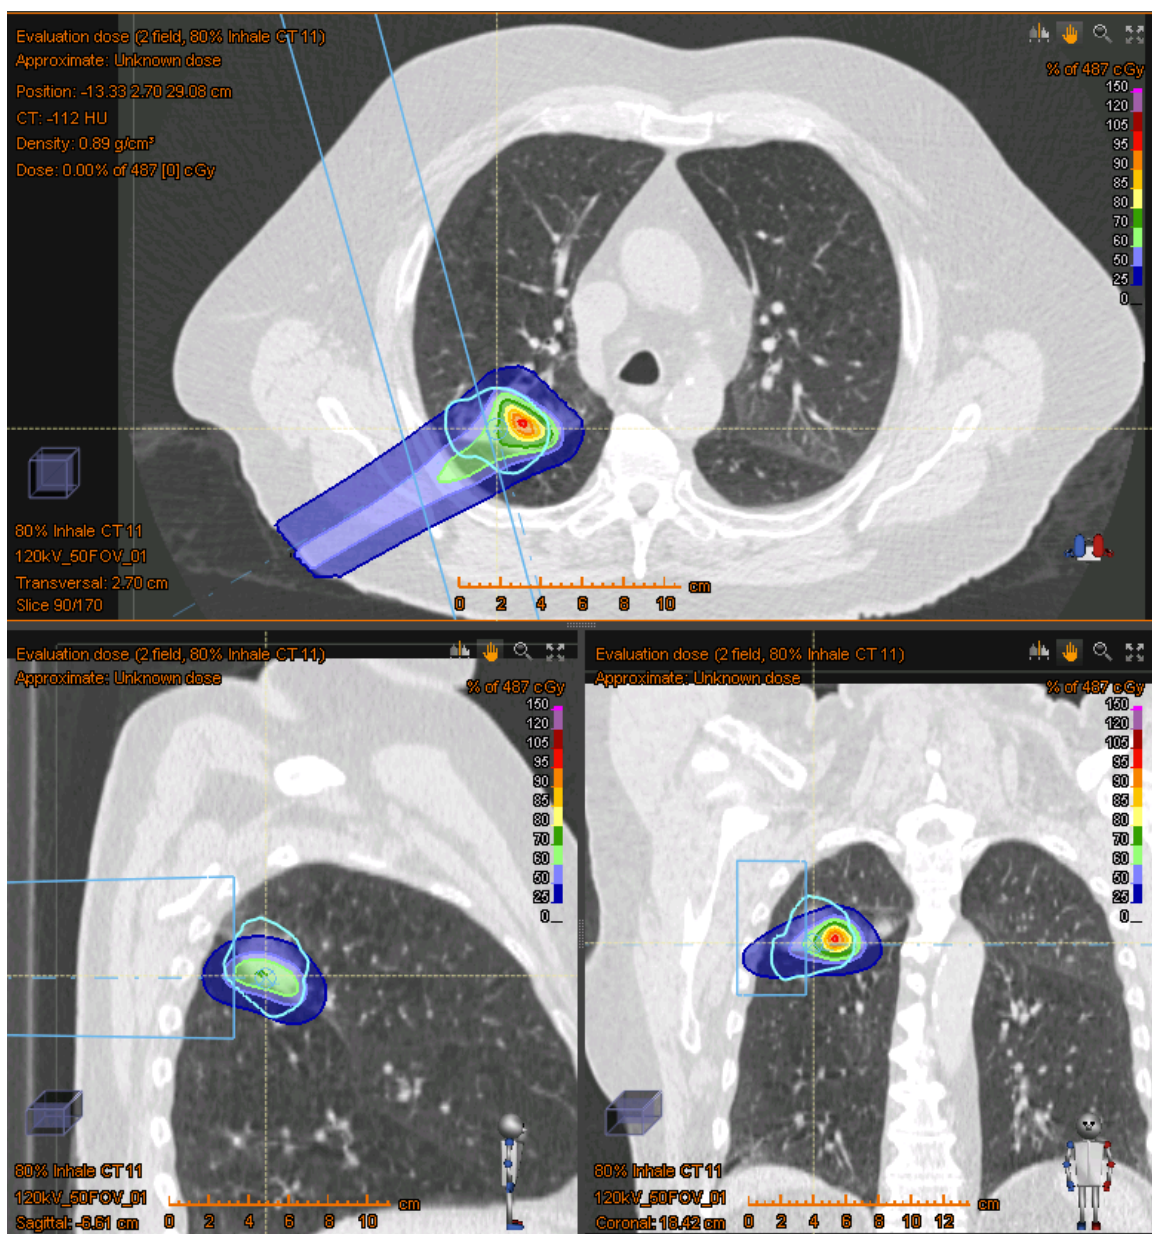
Field 1&2 – Dose delivered to 80% inhale CT phase
